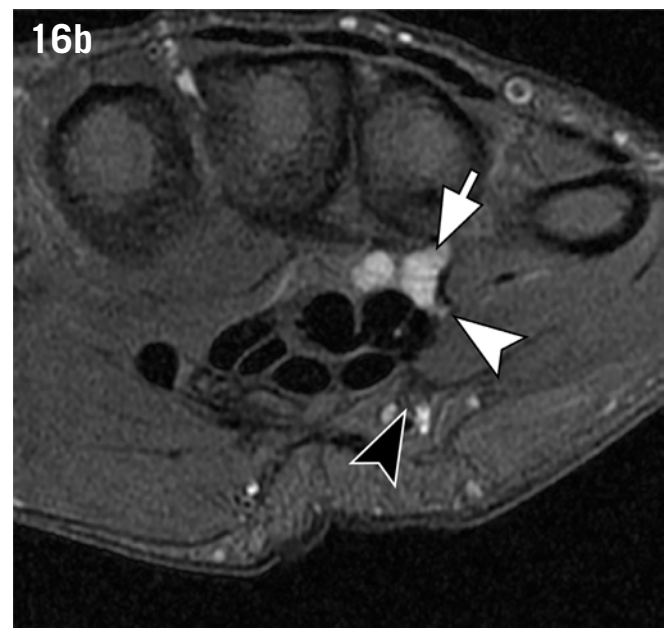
Ulnar nerve entrapment at the wrist. Axial T1-weighted (a) and T2-weighted fat-suppressed (b) images of the wrist. There is a cyst (arrow) compressing the deep branch of the ulnar nerve (white arrowhead). The superficial branch of the ulnar nerve is normal (black arrowhead).
